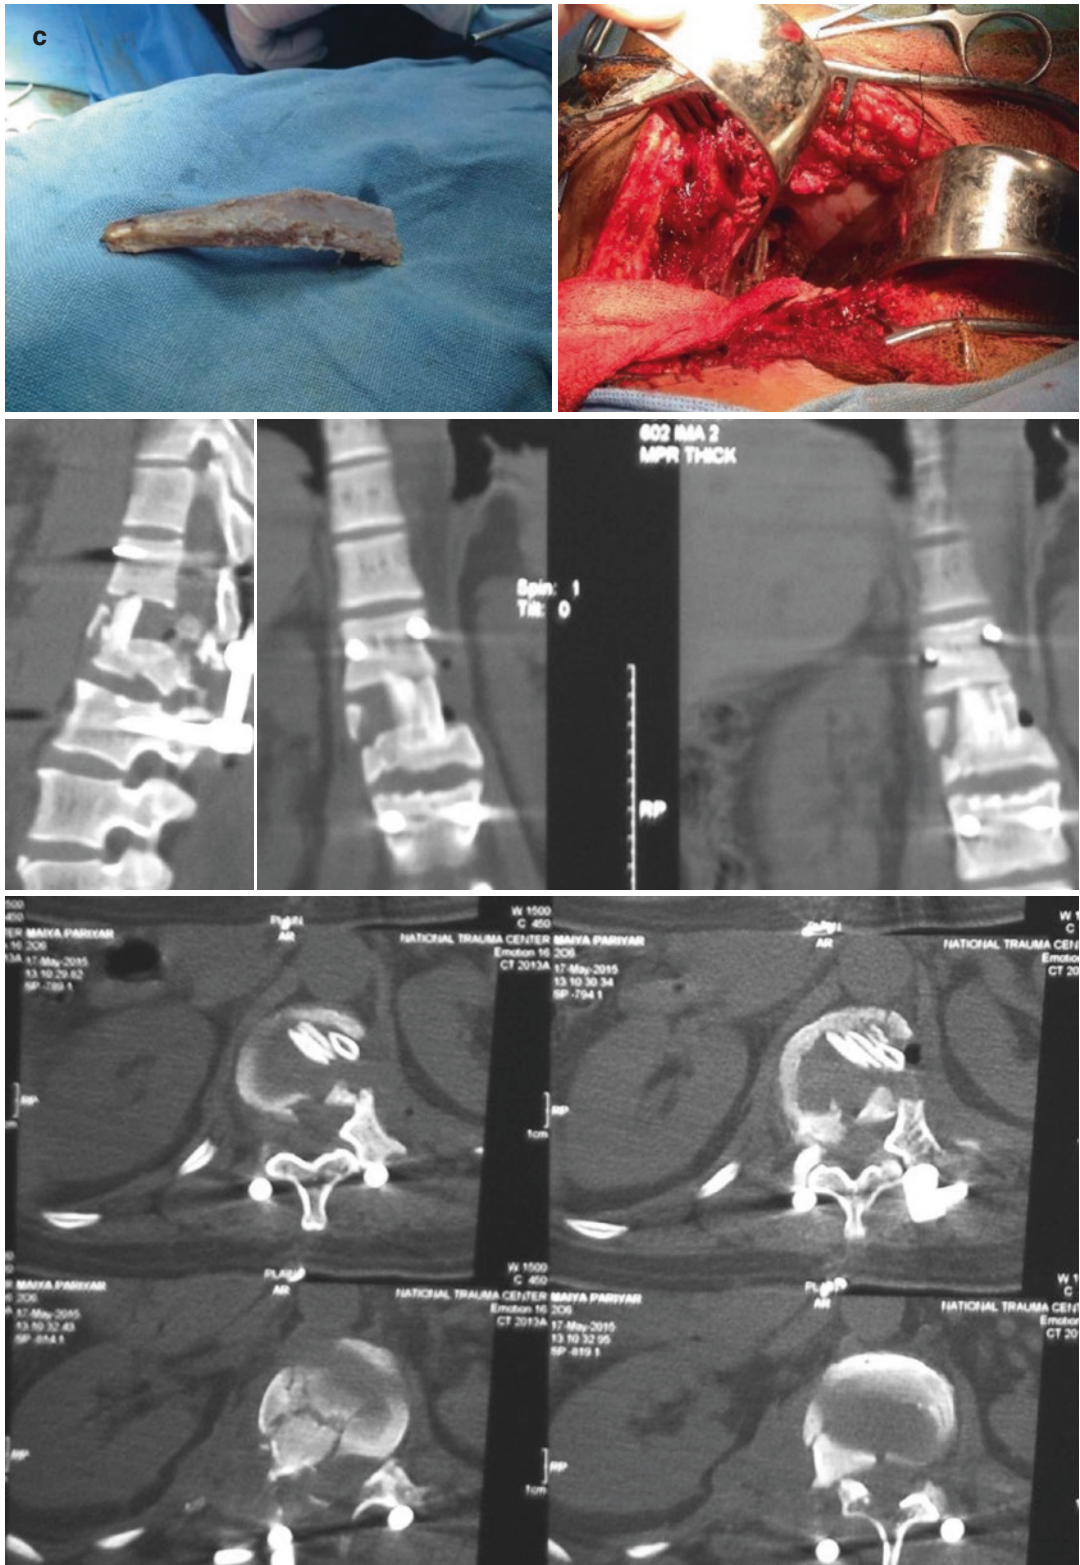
(continued) (c) Transthoracic stabilization. A partial corpectomy of L1 and disectomy of Th12–L1, decompression of the spinal cord, spondylodesis of L1 body by
